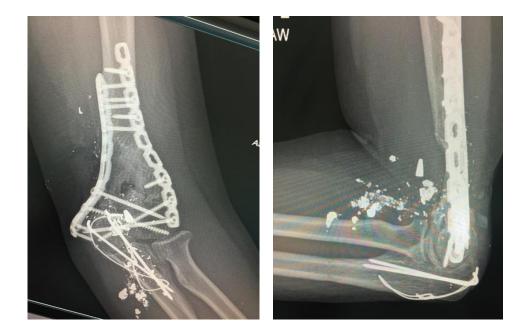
Final Xrays of left elbow post-op
